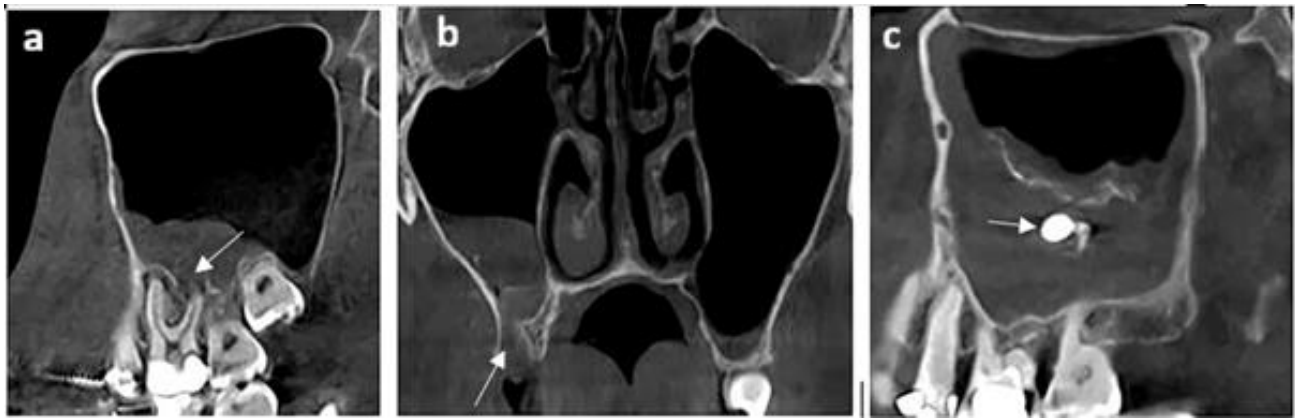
Cone-beam computed tomography (CBCT) images of dental pathologies: a. periapical lesion (sagittal view) b. post-extraction perforation (coronal view) c. foreign body (sagittal view)
